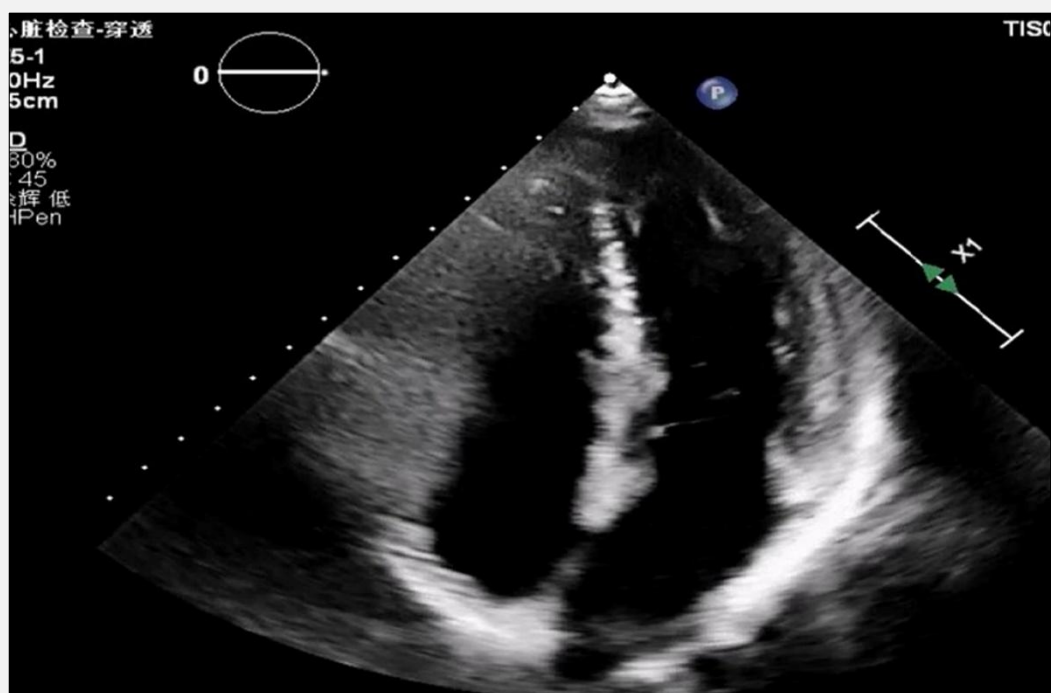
Echocardiogram of the patient at the 9th month of follow-up.
